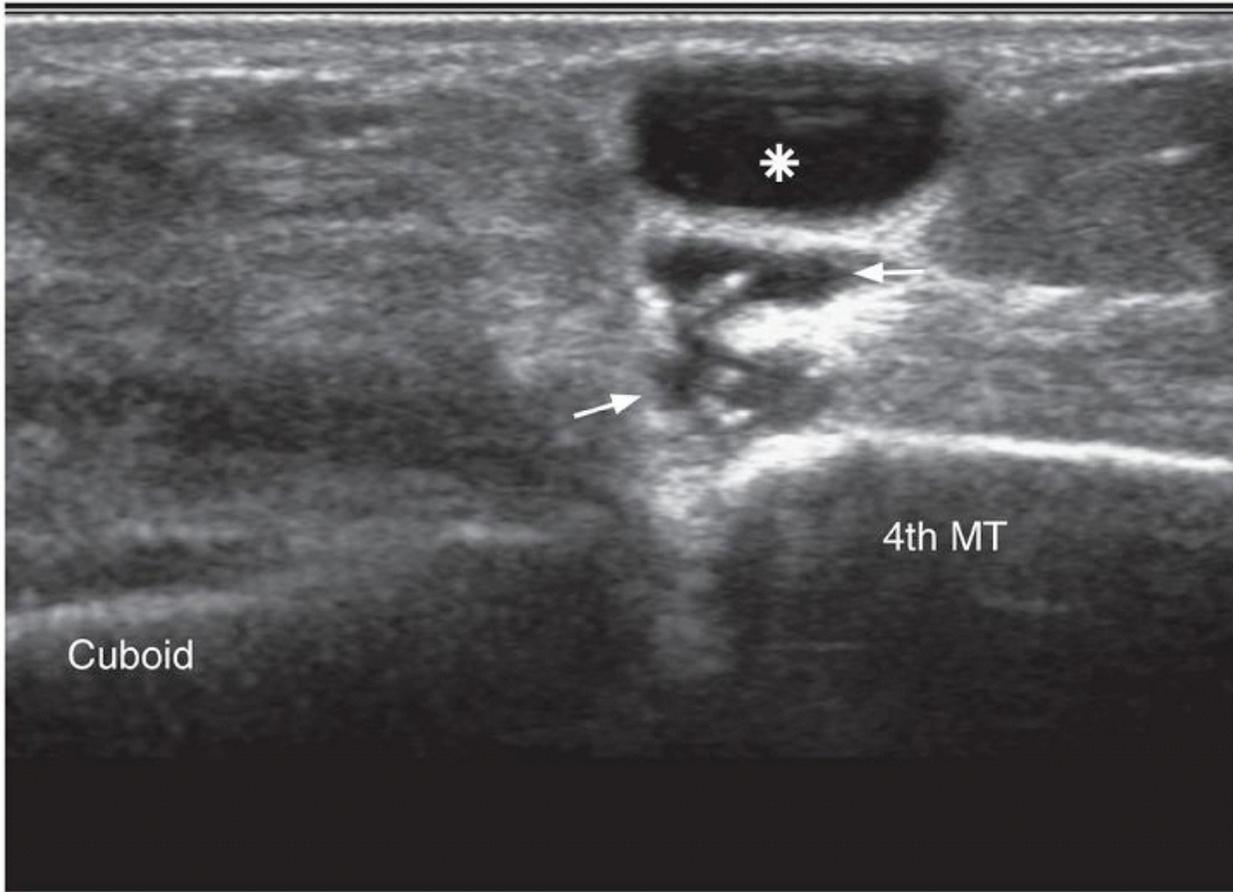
Longitudinal ultrasound of dorsum of foot showing medium-sized ganglion cyst (asterisk) with serpiginous track (arrows) leading to cuboid: 4th metatarsal (4th MT) articulation.
